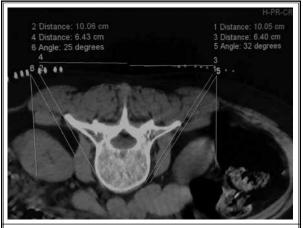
CT scan of the puncture path in chemical lumbar sympathectomy.
